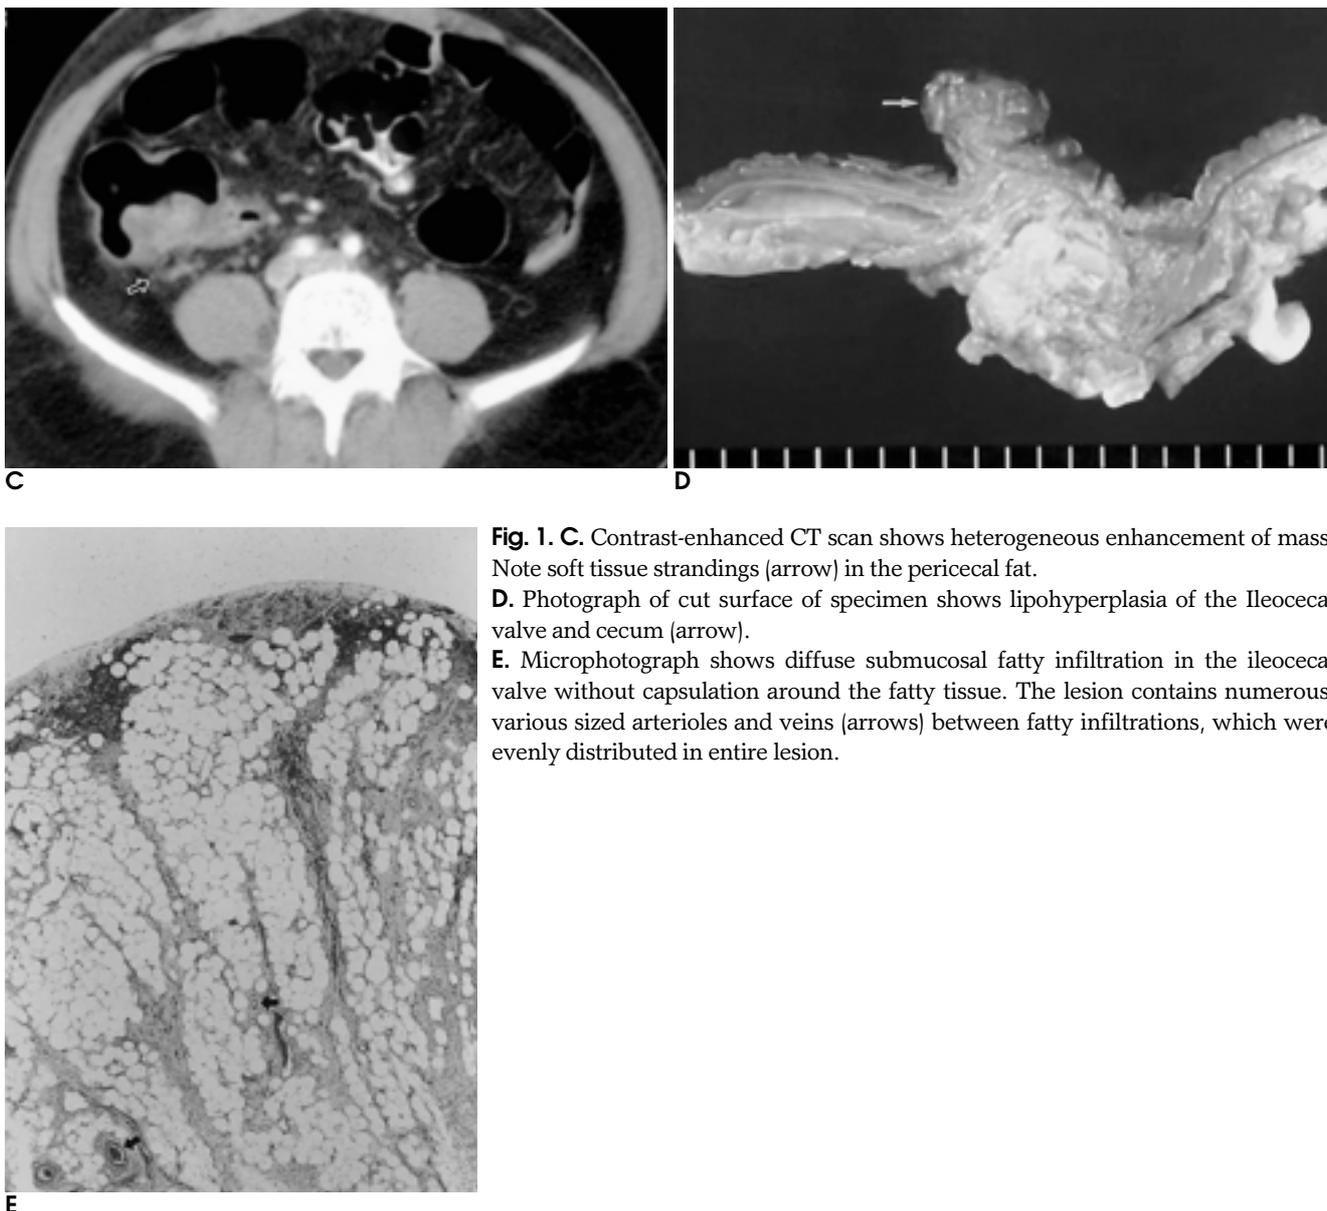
C. Contrast-enhanced CT scan shows heterogeneous enhancement of mass. Note soft tissue strandings (arrow) in the pericecal fat.
